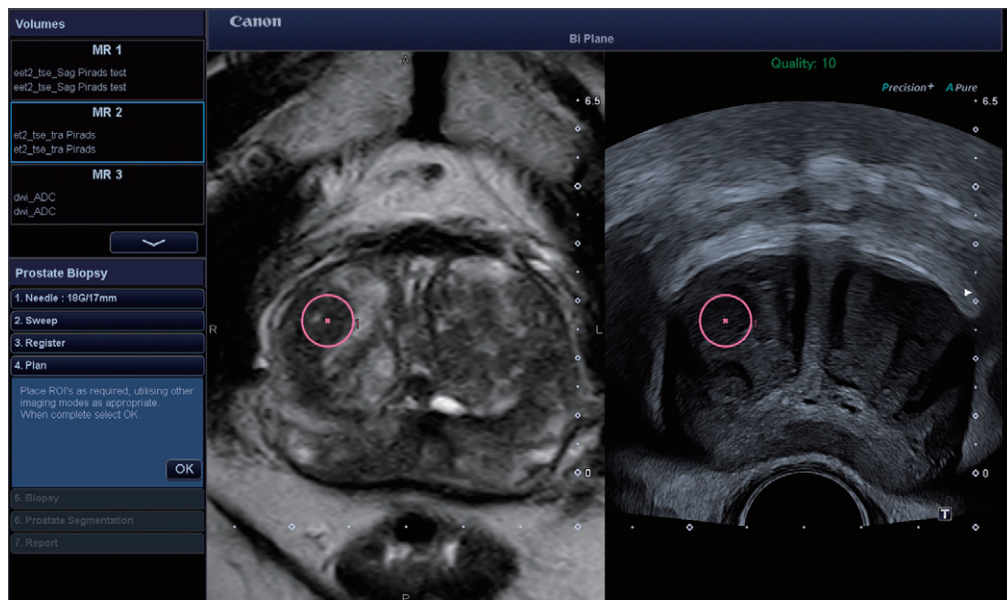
ROIs are showing simultaneously on both the live TRUS and MRI images for user-friendly navigation.
